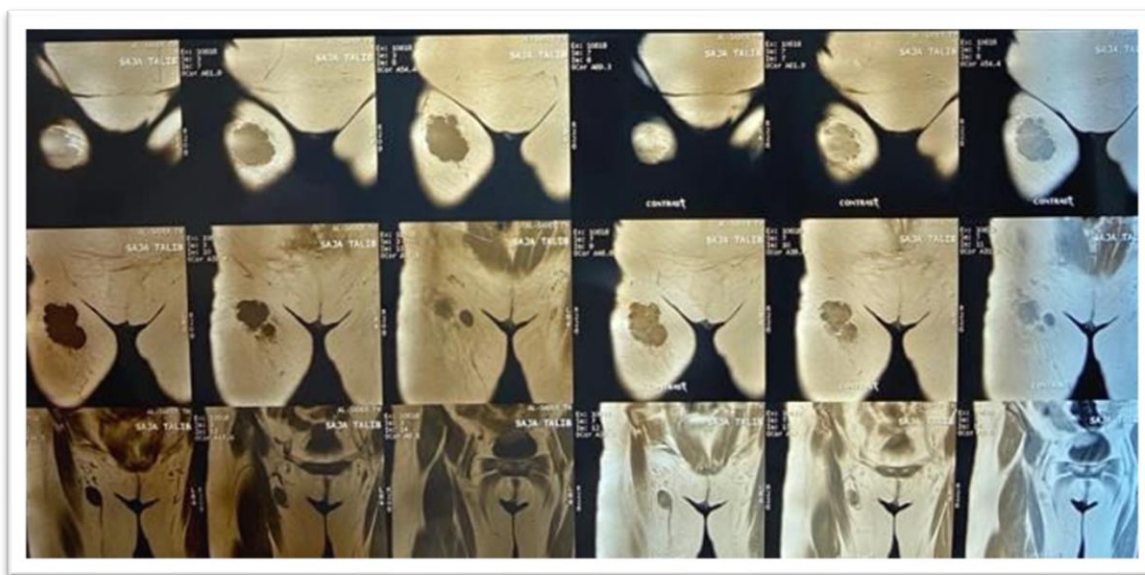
T 1- weighted magnetic resonance imaging (MRI) shows a low- intensity mass confined to the subcutaneous area and extending to cutaneous tissue. A: T 1- weighted images without contrast B: with contrast
